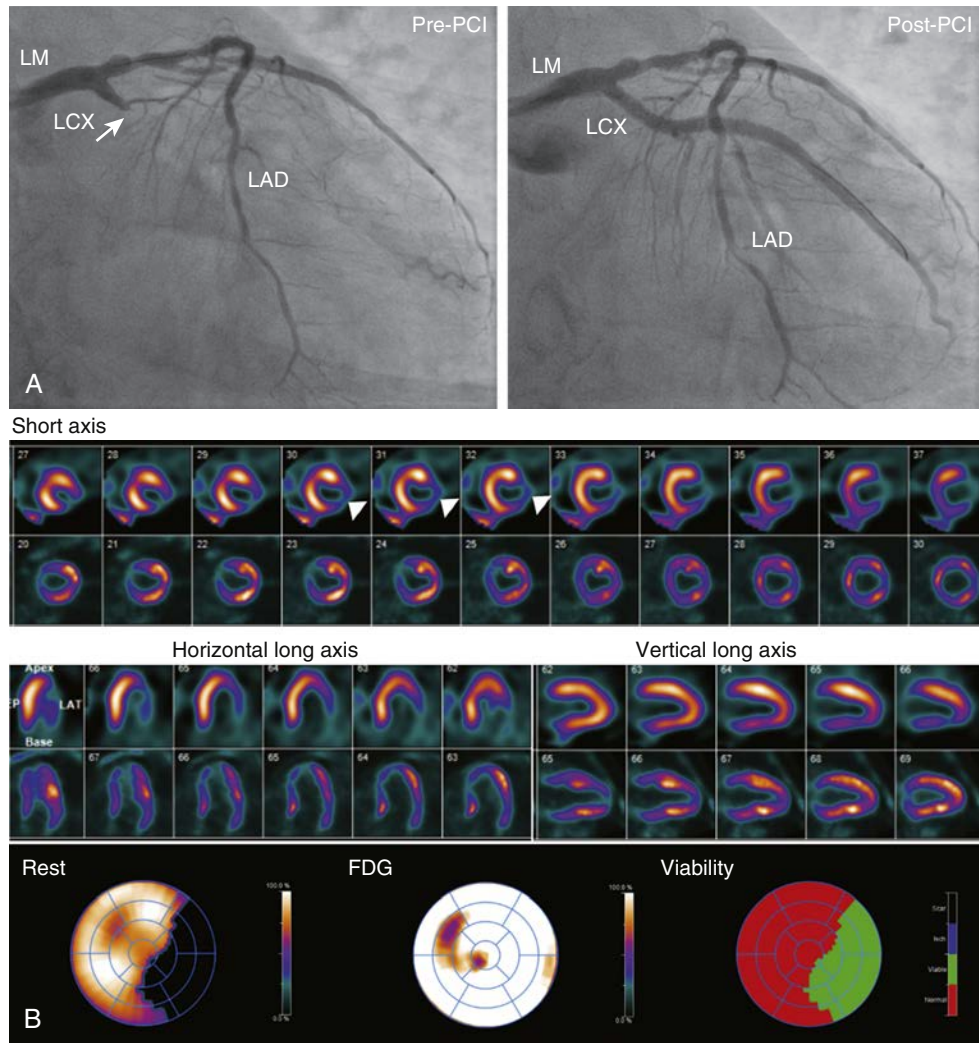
Images for Case Vignette 4. (A) Coronary angiographic images. (B) Corresponding rest perfusion and fluorodeoxyglucose-uptake positron emission tomography (FDG-PET) images. See text for details. LAD, Left anterior descending artery; LCx, left circumflex artery; LM, left main artery; PCI, percutaneous coronary intervention.
